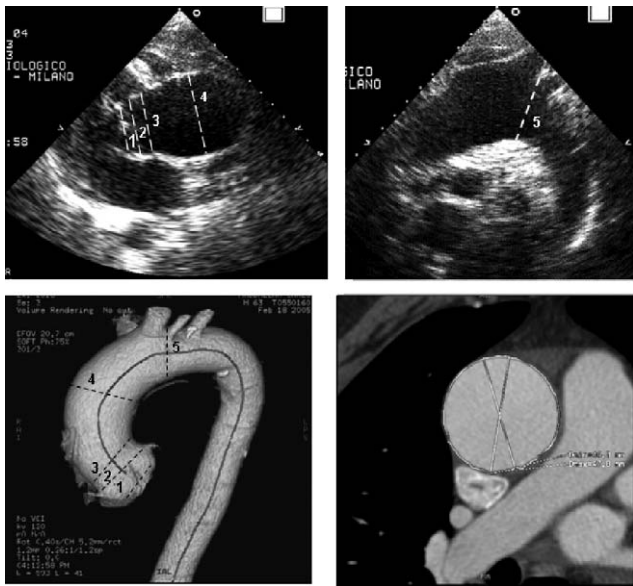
Example of measurement of the aortic dimensions. Upper panels, echocardiographic measurements (dashed lines) in parasternal (A) and suprasternal (B) views: 1 = aortic annulus, 2 = sinuses of Valsalva, 3 = sinotubular junction, 4 = ascending aorta, 5 = aortic arch. Lower panels, CT reconstructions of the aorta. CT measurements were obtained at the same echocardiographic levels (C); in each transverse section of the aorta (perpendicular to the long axis) the maximal diameter was considered (D).
